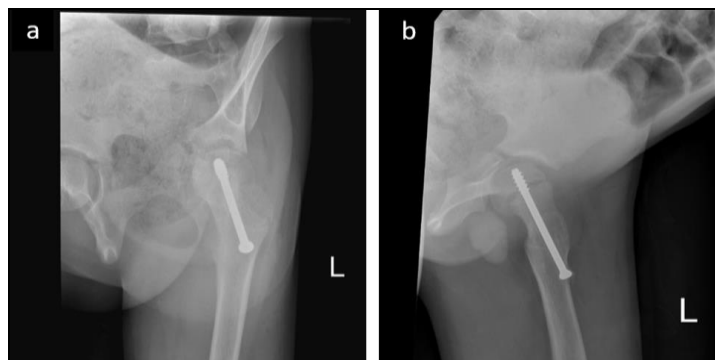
Radiographs of left hip anteroposterior (a) and lateral (b) views at 12-week follow-up.
